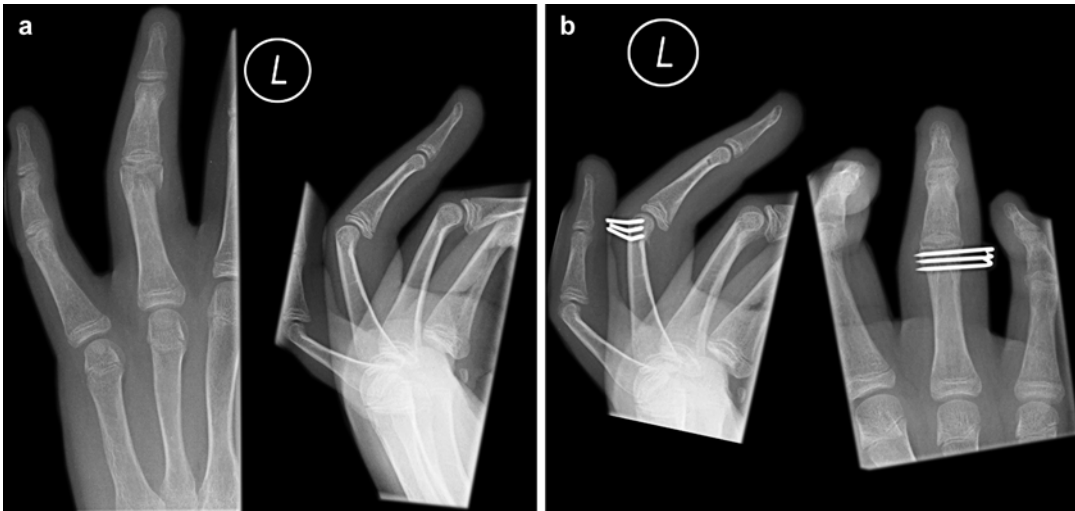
Radiographs of closed lateral K wiring of a unicondylar fracture. (a) preop, (b) post.op
